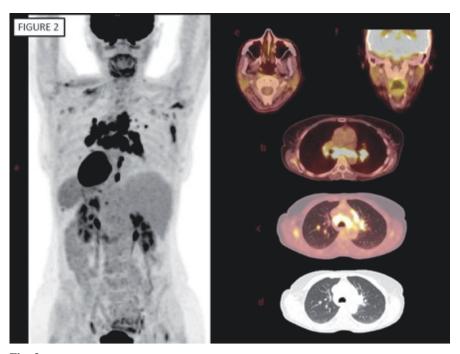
FDG PET scan in a patient diagnosed with pSS 13 years ago, who presented with fever of unknown origin. Whole-body FDG PET scan (a) shows hypermetabolic mediastinal/hilar lymph (b) and pulmonary (c y d) nodes in axial images. The distribution of active lymph nodes and the presence of active pulmonary nodes suggest active sarcoid inflammation, that has to be confirmed to discard a lymphoproliferative syndrome. PET guide biopsy toward the most hypermetabolic structure (subcarinal node) and the diagnosis of sarcoidosis was made. Moderate hypermetabolism was seen in salivary glands: a) whole body, e) axial and f) coronal images.
